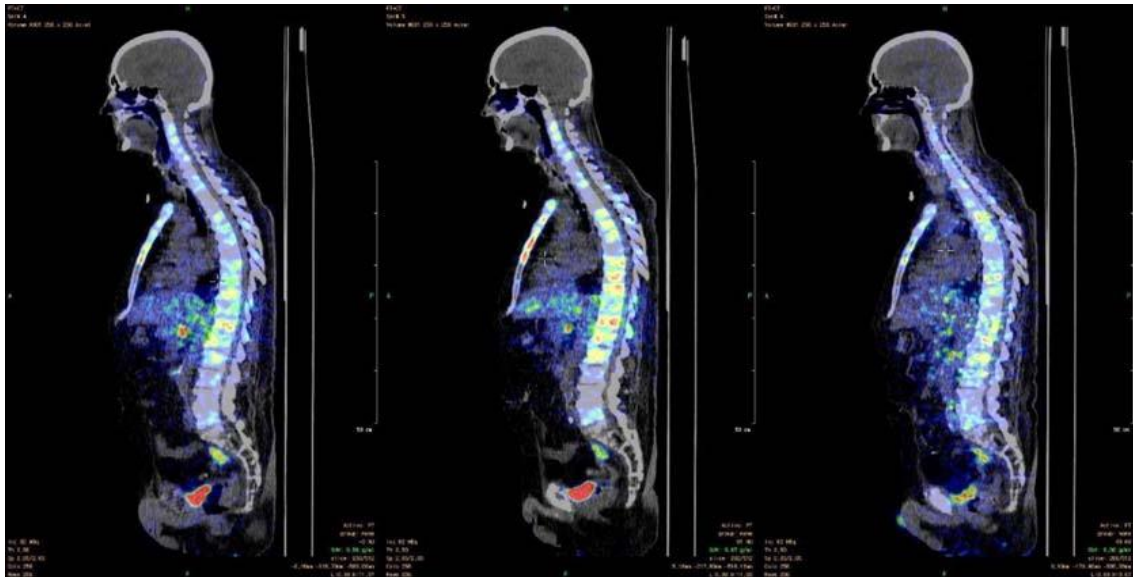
Verteilung von $[^{44}\text{Sc}]\text{Sc-PSMA-617}$ nach 45 Minuten sowie 2 und 19,5 Stunden nach der Injektion (von links nach rechts) (siehe auch S. 160).
